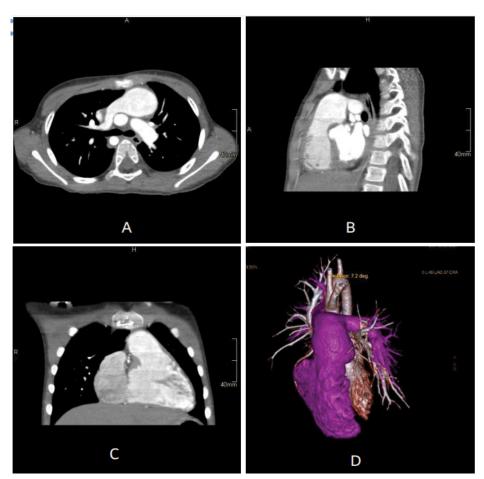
4 years old child chest CT angiogram images (A) axial (C) coronal, (B) sagittal and (D) 3D reconstruction.
